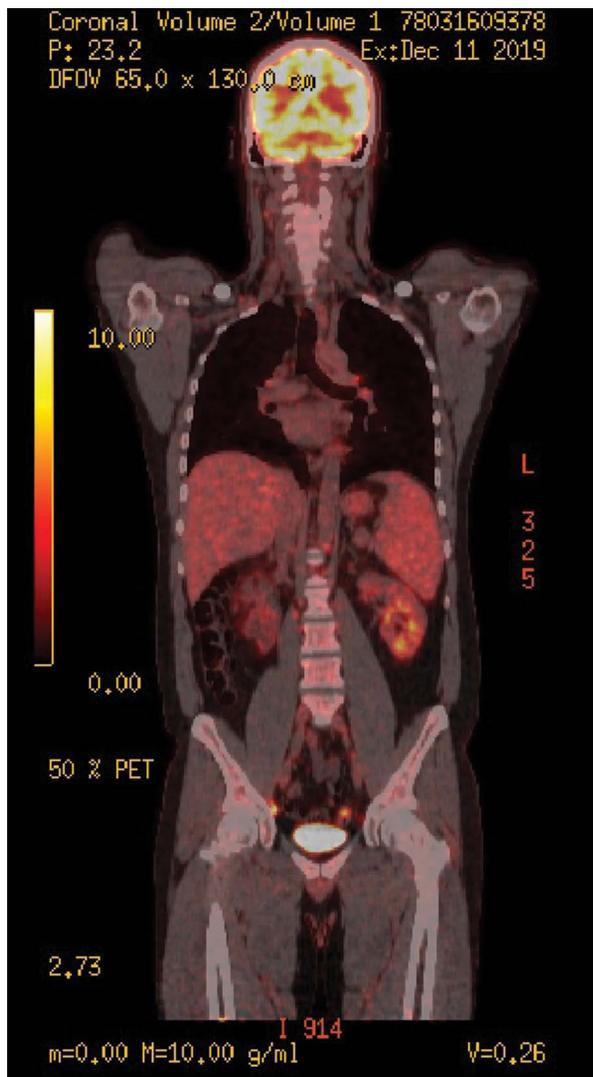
PET-CT coronal view. The patient with chronic sarcoidosis, presenting signs of radiological remission in most recent CT. PET was performed to exclude suspected extrathoracic manifestation of sarcoidosis. Increased uptake of 18F-FDG in cervical, intrathoracic and pelvic lymph nodes
